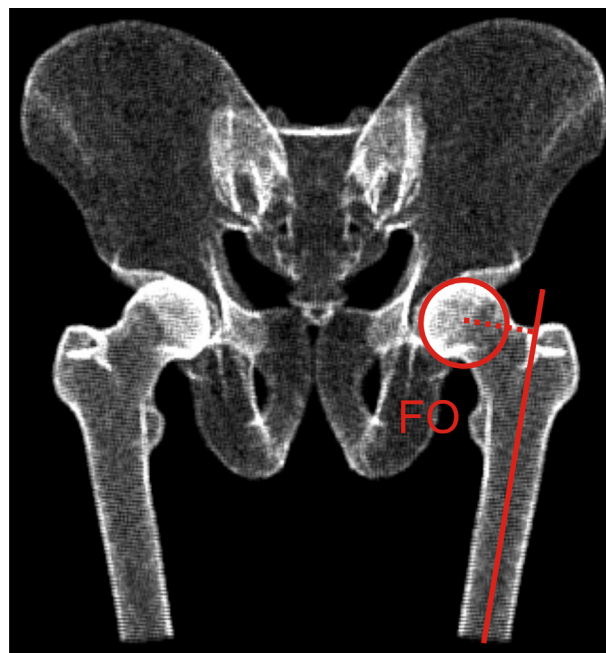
Synthetic anteroposterior X-ray showing the femoral offset (FO) measured in preoperative planning.
